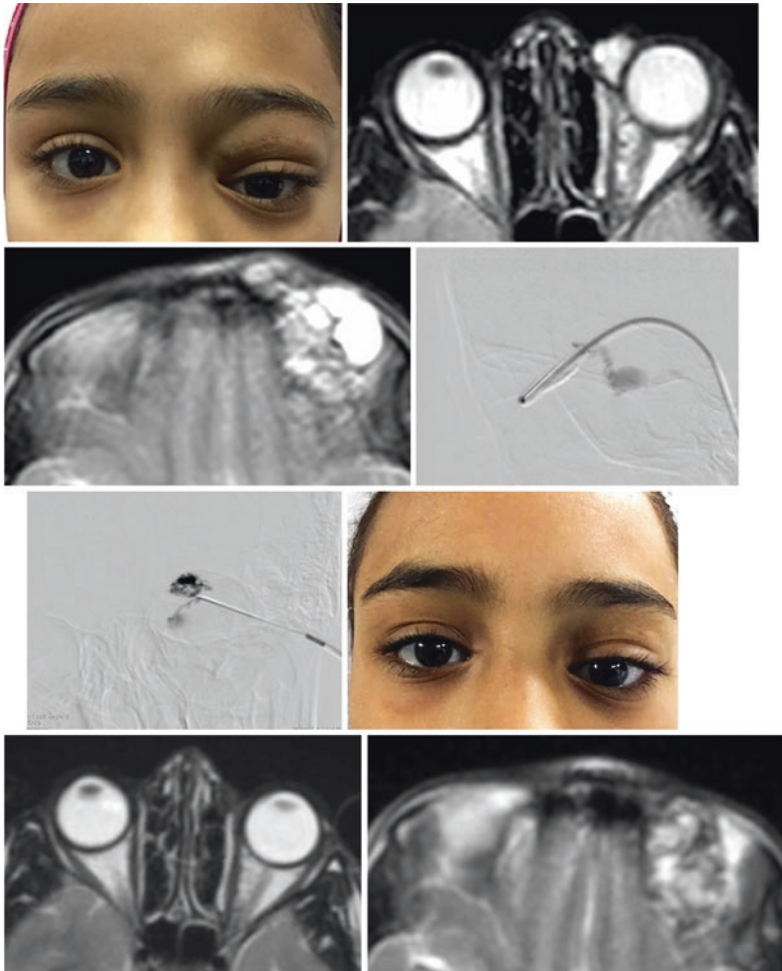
Sclerotherapy of orbital lymphatic malformation in a 9 years old girl presenting with proptosis and dystopia. a Pre-procedure clinical photo showing inferior displacement of the left eye globe with focal mass at the left frontal region. b, c Axial T2W images demonstrate mixed left orbital lymphatic malformation which has a large preseptal mainly macrocystic component extending to the left frontal region and a smaller deep intraconal microcystic component. d, e The patient underwent repeated sessions of image-guided bleomycin sclerotherapy. Digital subtraction images at two different sessions showing opacification of different non-communicating cystic compartments of the lesion. f–h Follow up clinical and MRI images obtained one year after treatment show considerable improvement. Axial T2WI demonstrate reduction of the size of the lesion with residual low signal intensity of fibrosis (Case courtesy of Dr. Omar Abdelaziz, Cairo University)
